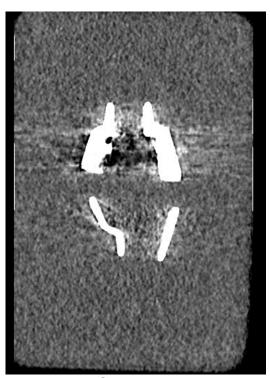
CT* scan showing the lateral view of both cones, this image shows streaking artefact
